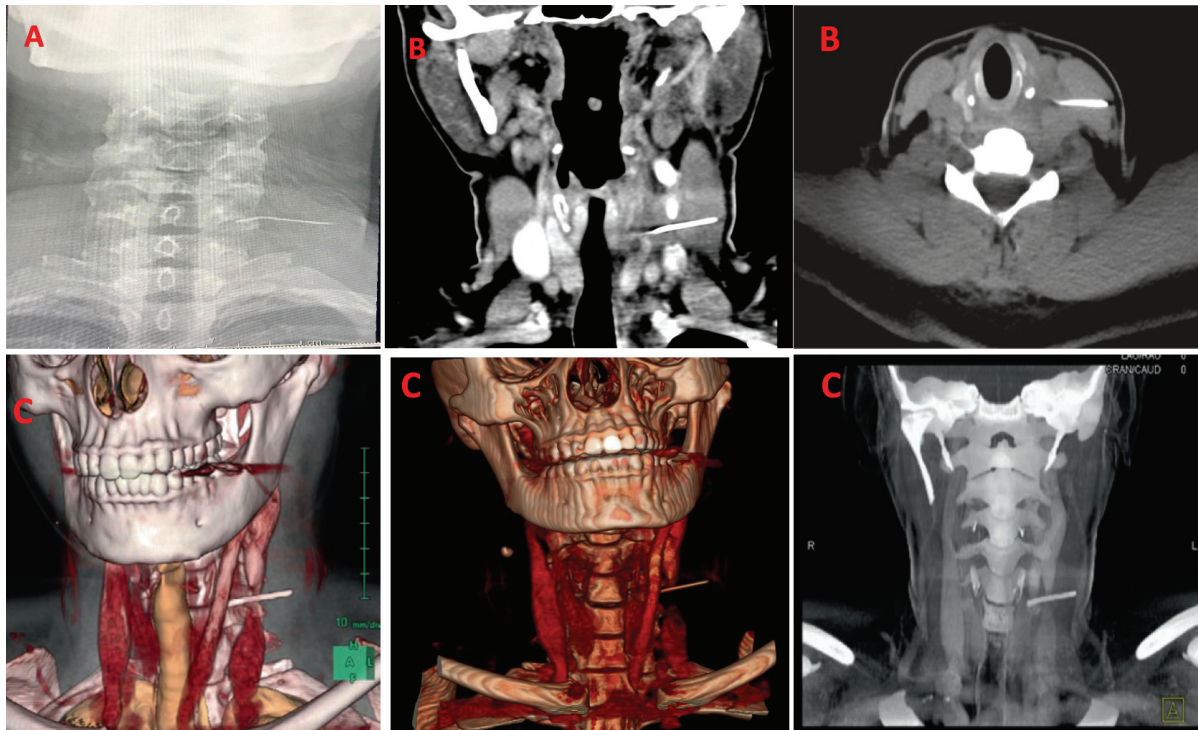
A: X-ray showed a long, thin, smooth, and impinged foreign body (FB) at the C5-C6 level, lying lateral to the esophagus. B: Computed tomography (CT) of the neck confirmed a metallic density FB, that was 3 cm in length, had pierced through the left internal jugular vein (IJV), and the left sternocleidomastoid muscle (SCM). C: 3-dimensional (3D) reconstructed images.
